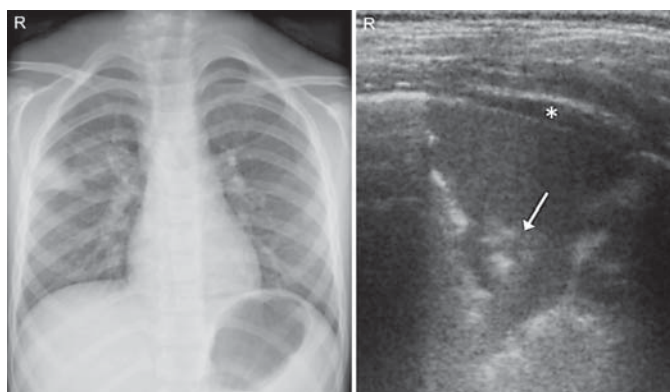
A 5-year-old male with fever, cough and pleuritic chest pain. CXR was performed in posteroanterior view. Sonography was performed in the upright position with a linear probe (7.5 MHz) in B-mode. Radiography and ultrasound confirmed the diagnoses of pneumonia by showing a subpleural lung consolidation, and a transversal sonographic scan revealed a consolidation with air bronchogram (white spots highlighted by the arrow) and a minimal pleural effusion (asterisk). R = Right side. 70 kV; 2 mAs.
